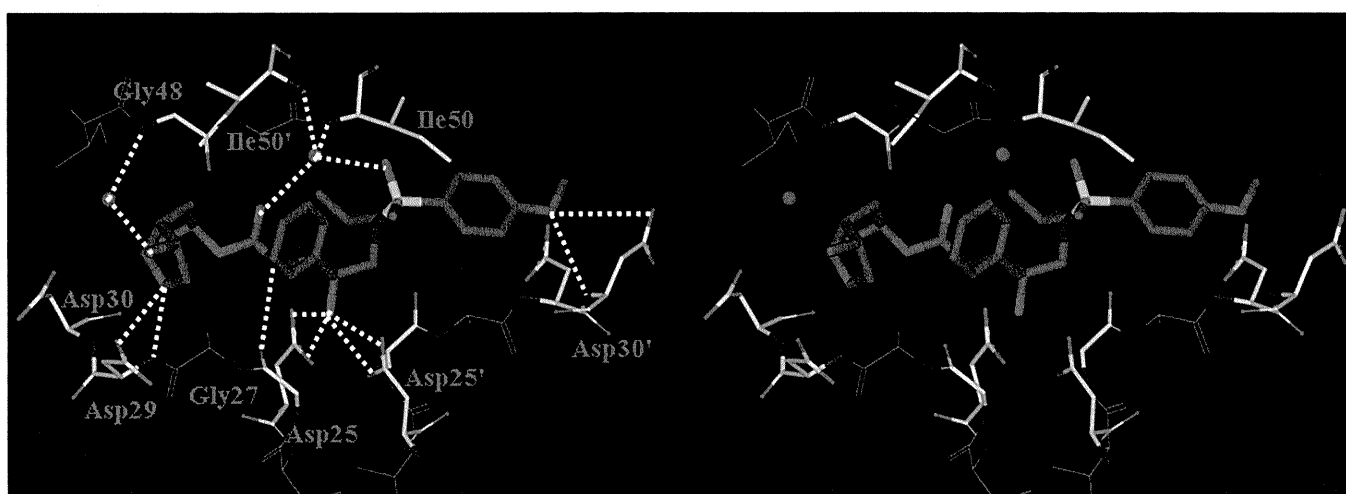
Stereoview of the X-ray structure of inhibitor 26 bound to the active site of the wild-type HIV-1 protease.
